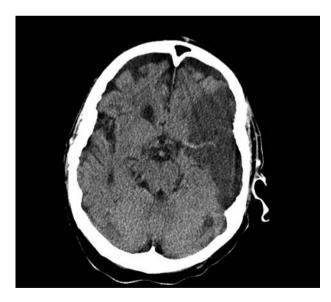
Later head CT (day 2) revealing hypodensity within the left MCA distribution
